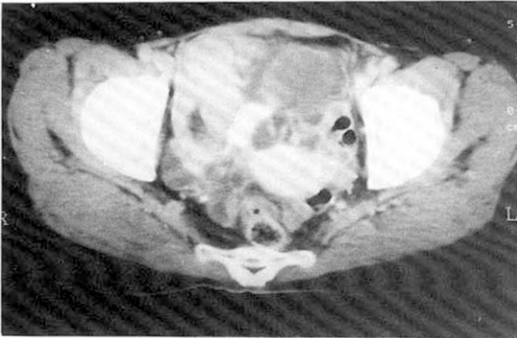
Abdominal CT scan shows round solid mass in right anterior supravescical space.
